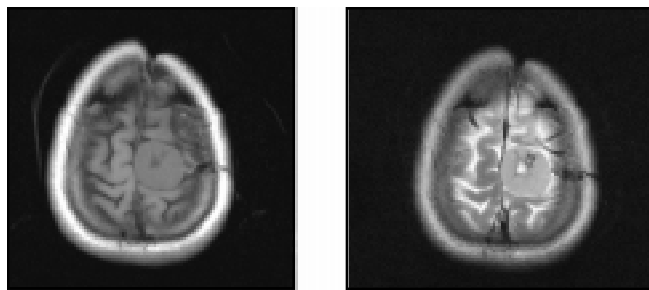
MRI brain showing left high parietal iso-intense lesion with few signal void areas and peri-lesional edema on T1 and T2 weighted images
